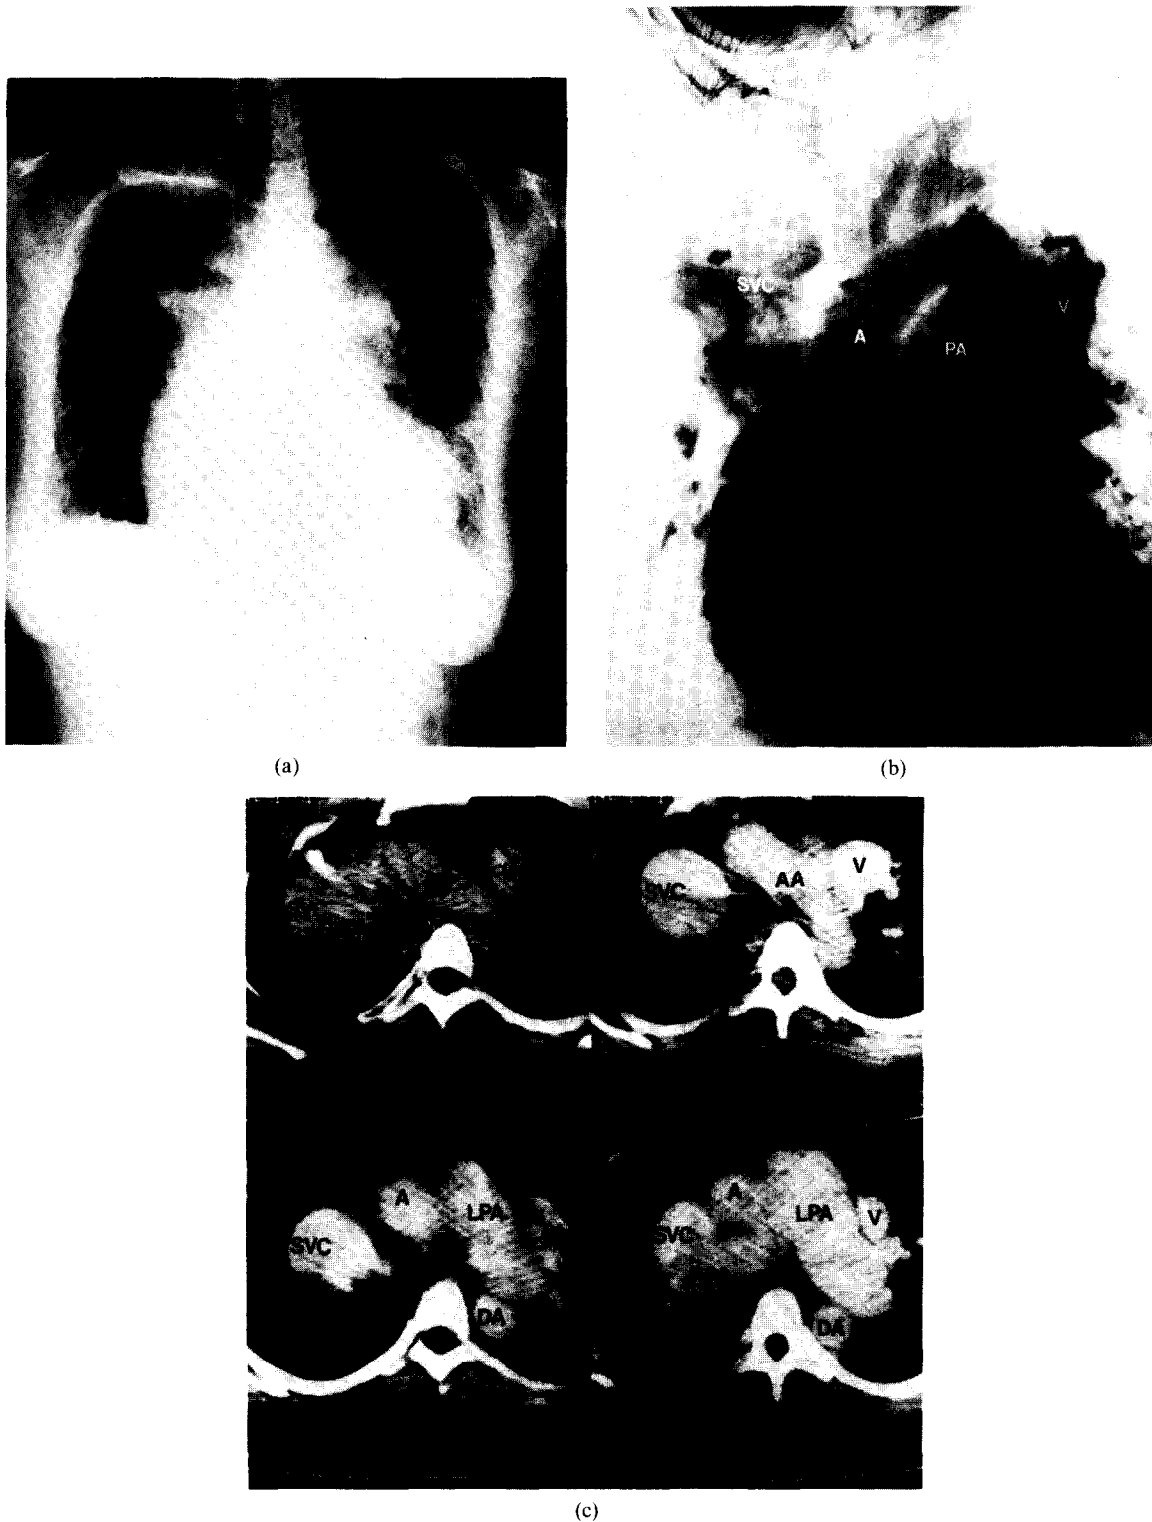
Patient 1.* Supracardiac anomalous venous return. (a) Posteroanterior chest radiograph reveals abnormal cardiac and mediastinal contour, with a "figure eight" configuration. Pulmonary and lymph node calcifications and partial right thoracoplasty reflect old tuberculosis. (b) Subtraction view from right ventricular contrast injection demonstrates left vertical vein (V), left brachiocephalic vein (B) overlying branches of aortic arch, and faintly opacified and enlarged superior vena cava (SVC). A = ascending aorta, PA = pulmonary artery overlying descending aorta. (c) Contiguous CT sections from aortic arch to pulmonary arteries show enhancement of left vertical vein (V) and enlarged superior vena cava (SVC). AA = aortic arch, A = ascending aorta, DA = descending aorta, LPA = left pulmonary artery, RPA = right pulmonary artery.
